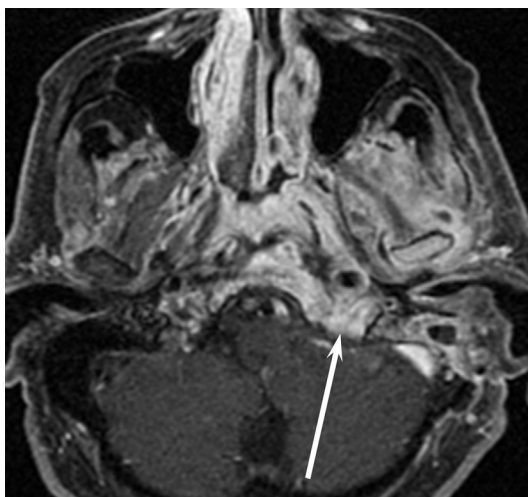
Skull base osteomyelitis causing hypoglossal denervation. Axial-enhanced T1-weighted image shows extensive enhancement of the left skull base and surrounding tissues, in particular the hypoglossal canal (arrow).
